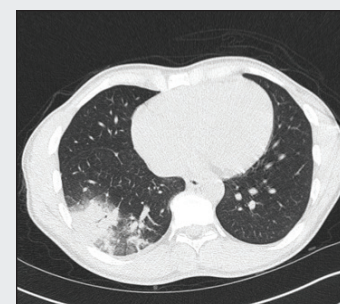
CT scan of the chest showing consolidation in lower lobe of right lung
